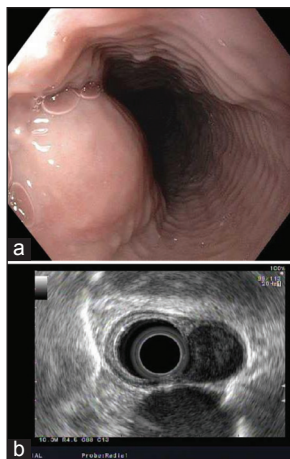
Esophageal leiomyoma. (a) Endoscopic image; (b) Endoscopic ultrasound image
